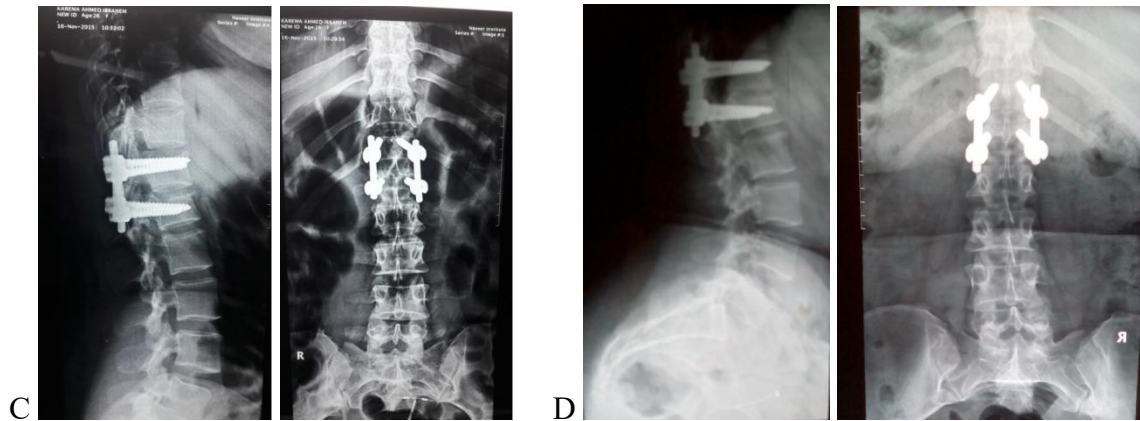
L1 burst fracture classified as A3.2 in Female patient, 27 years old, house wife as a result of Falling from height. (A) Preoperative anteroposterior and lateral radiograph. (B) Preoperative thoracolumbar spine computed tomography sagittal images. (C) images initial Postoperative anteroposterior and lateral radiographs. (D) One year follow-up anteroposterior and lateral radiograph.
